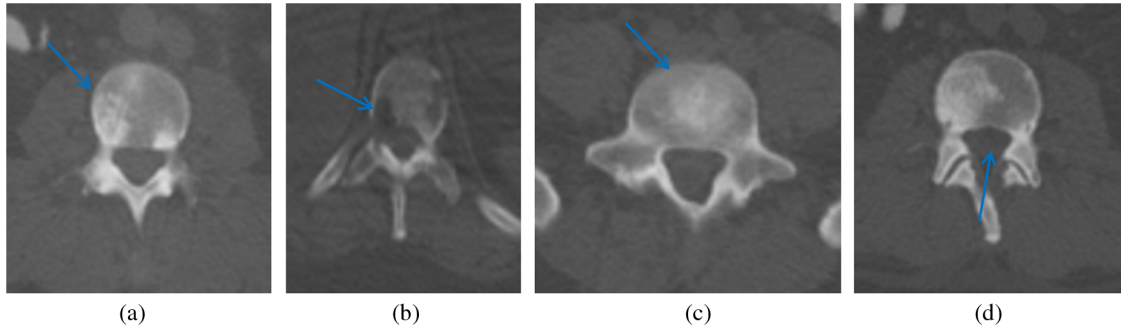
PET/CT synthesis. (a) Sclerotic synthesis of Fig. 1(a), sclerotic lesion becomes visible (arrow); (b) lytic synthesis of Fig. 1(b), mixed lesion is enhanced (arrow); (c) sclerotic synthesis of Fig. 1(c), mixed lesion is enhanced; and (d) lytic synthesis of Fig. 1(d), lytic lesion is enhanced.
